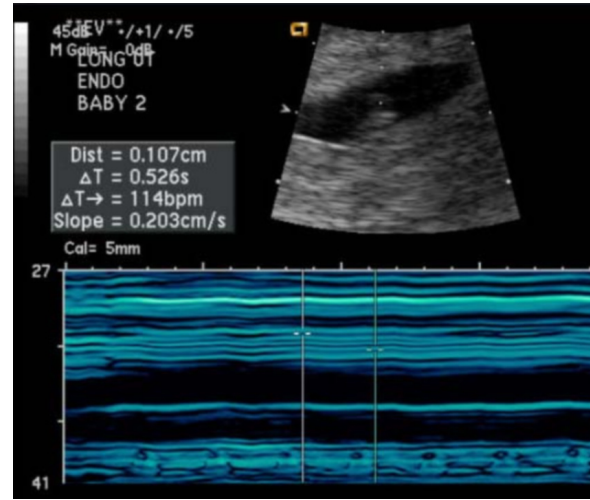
Transvaginal ultrasound showing cardiac activity at 114 beats per minute (BPM) in the intrauterine pregnancy.
